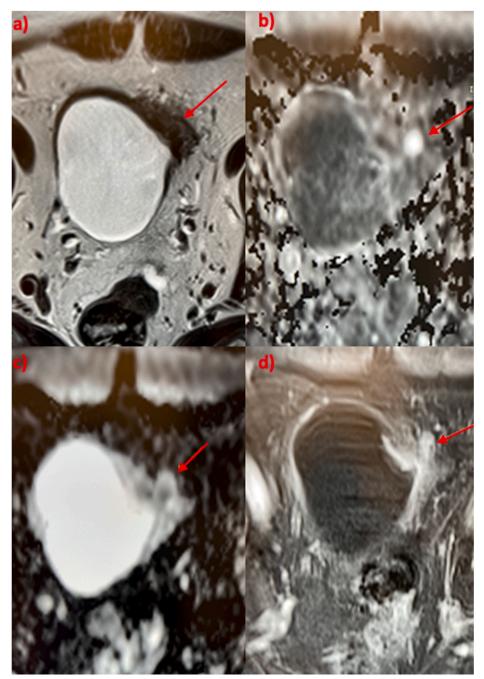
MRI Bladder performed 12 months after initial diagnosis (a) T2 weighted imaging demonstrates abnormal signal intensity and thickening affecting the muscularis and extending into the peri vesical fat. The diffusion weighted imaging shows diffusion restriction with bright signal in the extravesical nodule (b) and dark signal on the ADC map compatible with tumour recurrence (c). The muscularis demonstrates the opposite findings compatible with fibrosis or inflammation. (d) 30 second post-contrast image shows early enhancement in the extravesical nodule.
